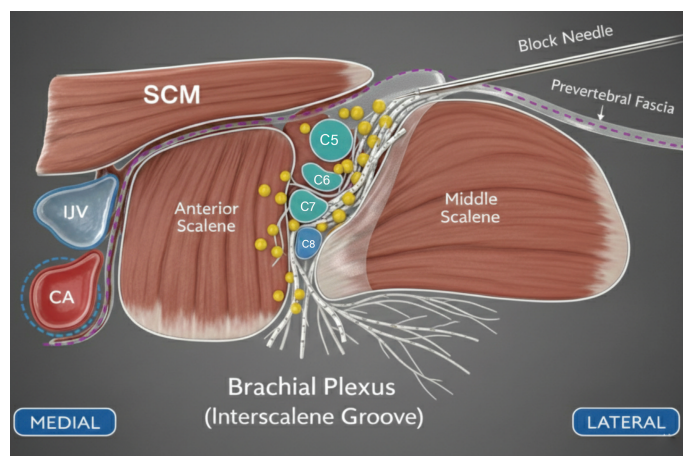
Ultrasound anatomy for interscalene brachial plexus block.
